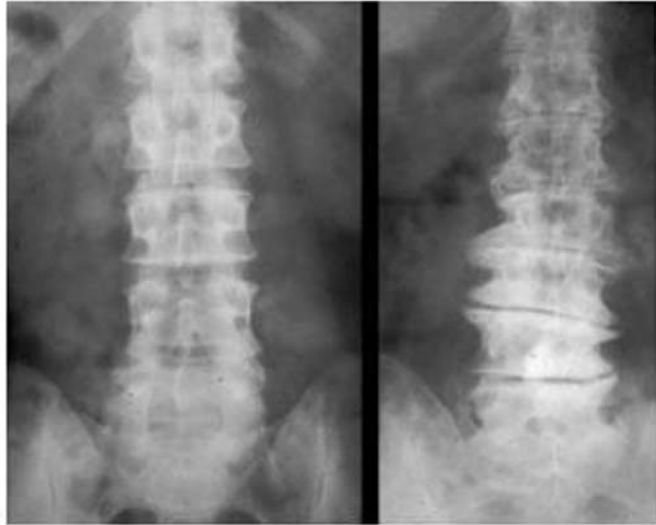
X-rays of lumbar spine. The patient on the left had been confined to bed for 2 years with back pain; the patient on the right had never had a day's back pain in her life.
